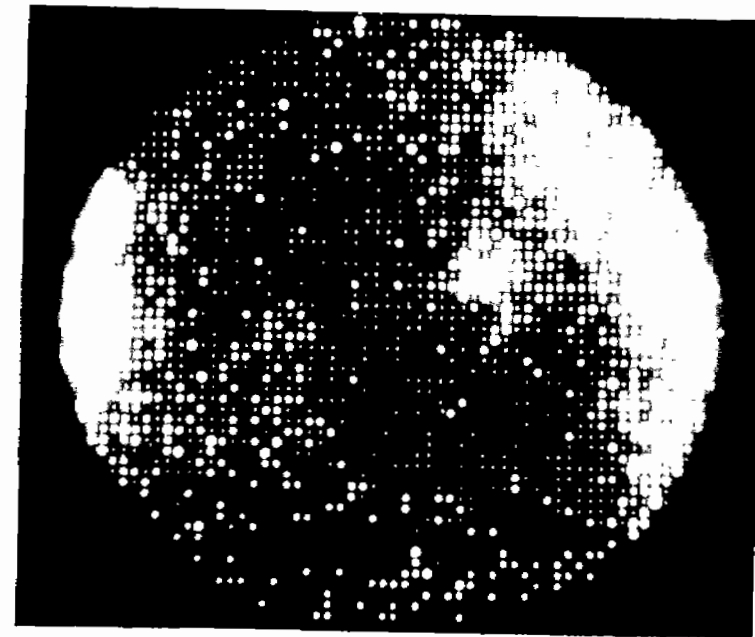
Abnormal dexamethasone suppression adrenal scintigram obtained 3 days after intravenous injection of NP-59 into a patient with hyperaldosteronism. Unilateral early breakthrough of adrenal visualization is indicative of adenoma.
